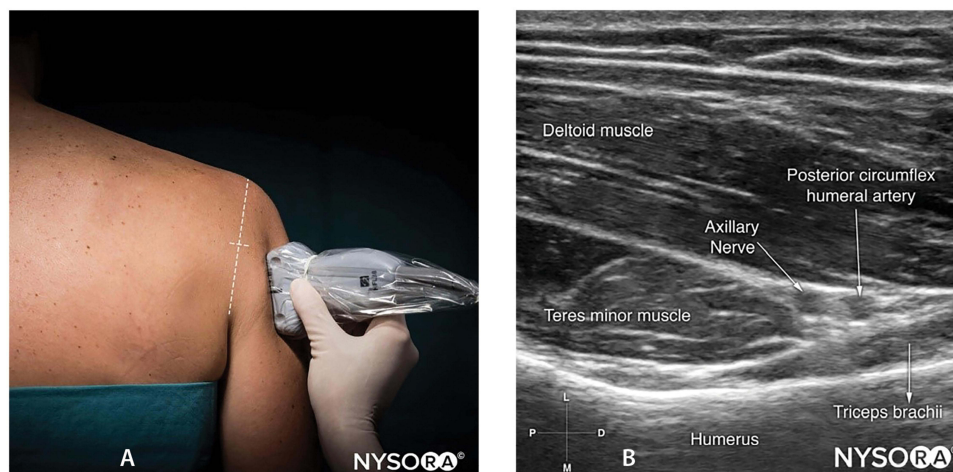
(A) Ultrasound transducer placement for accessing the axillary nerve; (B) Ultrasound image of the axillary nerve. Source: NYSORA.com. In compliance with ethical and academic standards, we acknowledge NYSORA, Inc. for granting permission to use the images in this article for educational purposes. All rights to these images remain with NYSORA, Inc.
